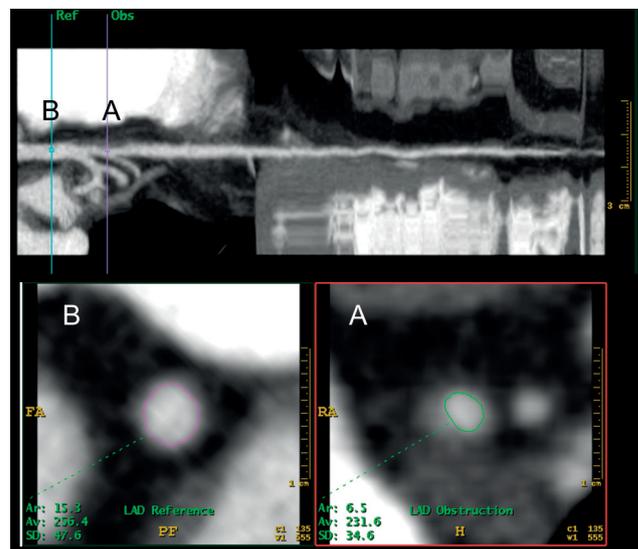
Example of a mild soft plaque located in the proximal left anterior descending artery (longitudinal MSCT view in the upper panel). The cross-sectional view obtained at the lesion site (lower Panel A) shows a non-significant lesion with a minimal lumen area of 6.5 mm², much larger than the threshold value of 3.5 mm² that has been validated for intravascular ultrasound analysis. The reference cross sectional area at MSCT is 11.3 mm² (lower Panel B).
